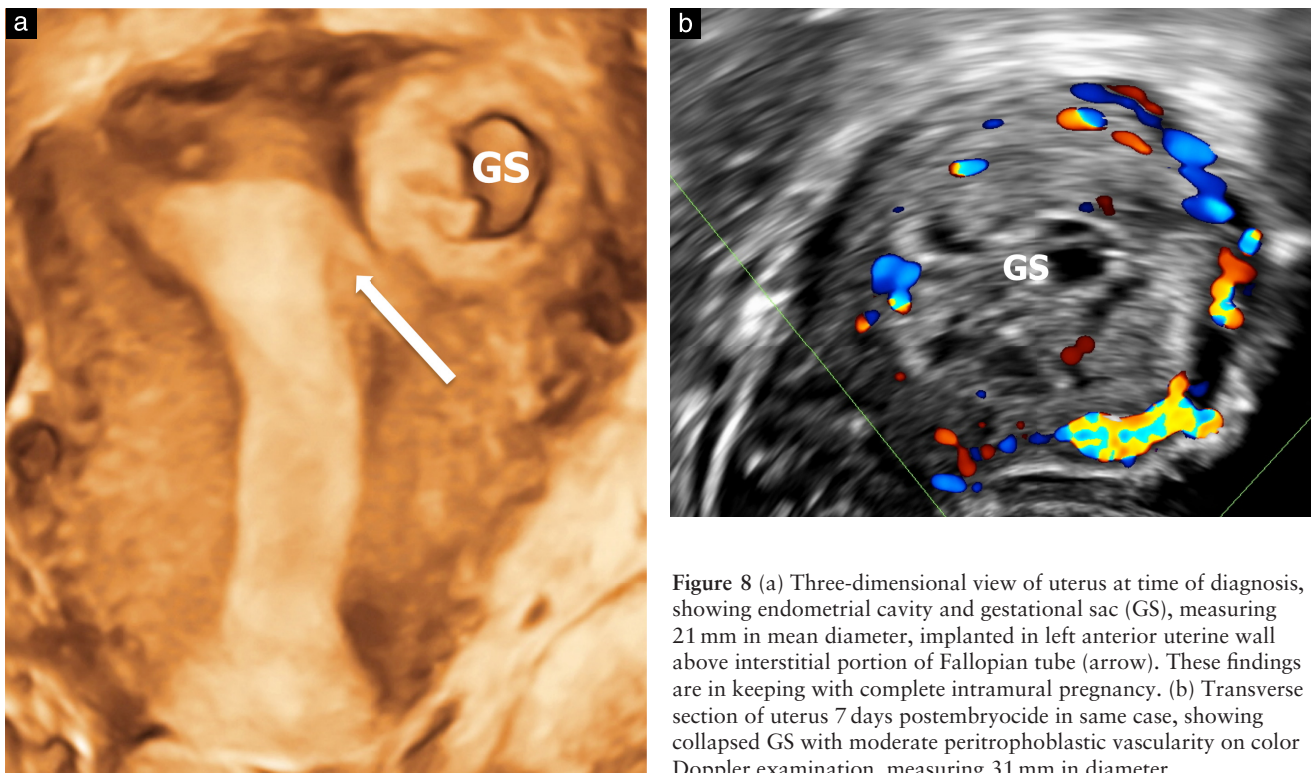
(a) Three-dimensional view of uterus at time of diagnosis, showing endometrial cavity and gestational sac (GS), measuring 21 mm in mean diameter, implanted in left anterior uterine wall above interstitial portion of Fallopian tube (arrow). These findings are in keeping with complete intramural pregnancy. (b) Transverse section of uterus 7 days postembryocide in same case, showing collapsed GS with moderate peritrophoblastic vascularity on color Doppler examination, measuring 31 mm in diameter.
